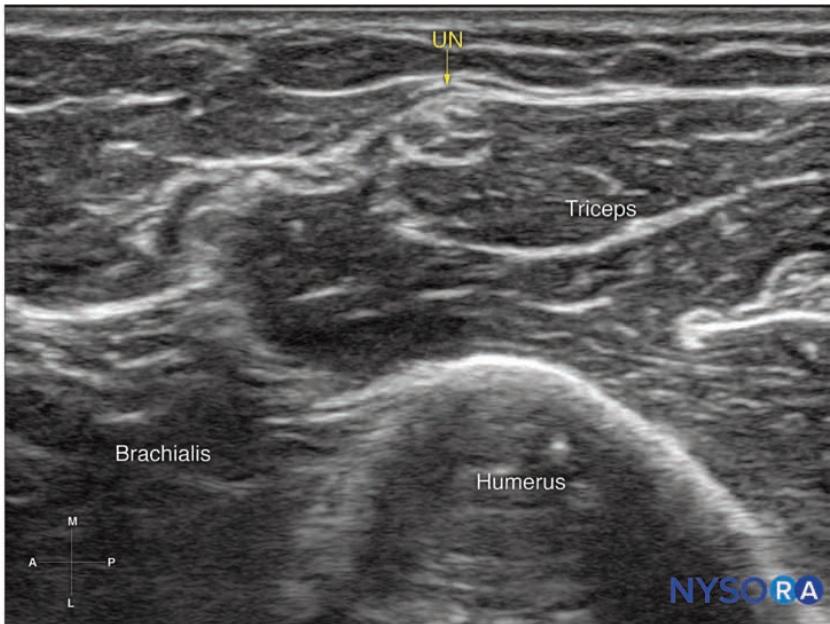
Probe position and ultrasound image of the ulnar nerve (UN) above the elbow.
